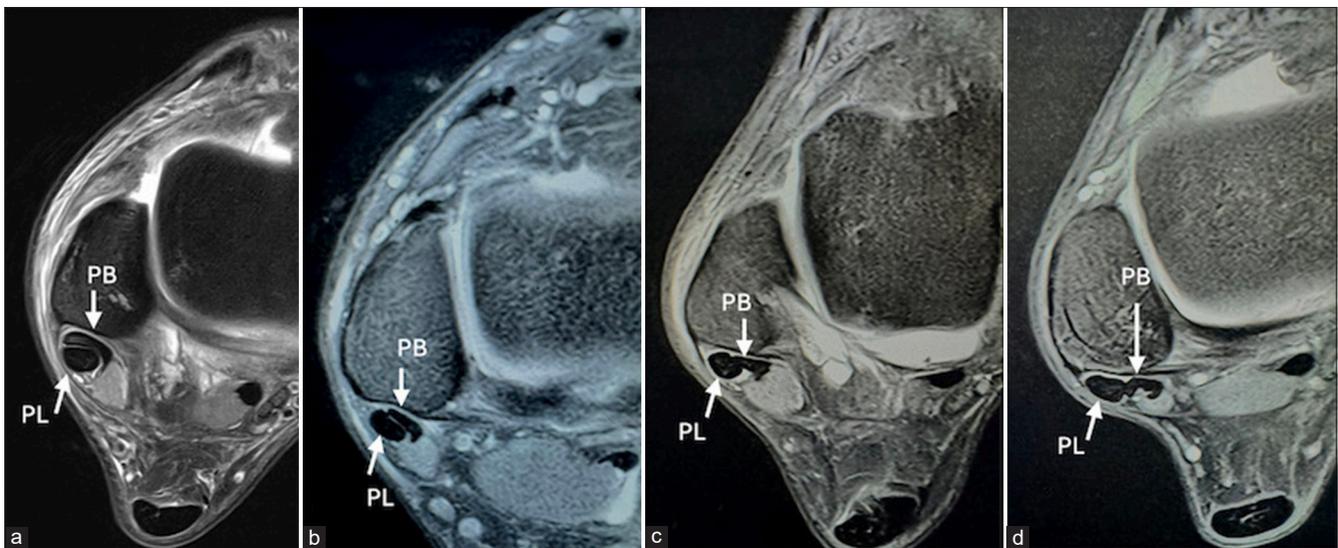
Proton density fat-suppressed axial MRI images at the level of retromalleolar groove of various types of spatial relationship of peroneal tendons [peroneus longus (PL) and peroneus brevis (PB)] (a) Type 1, (b) Type 2, (c) Type 3, and (d) Type 4.
